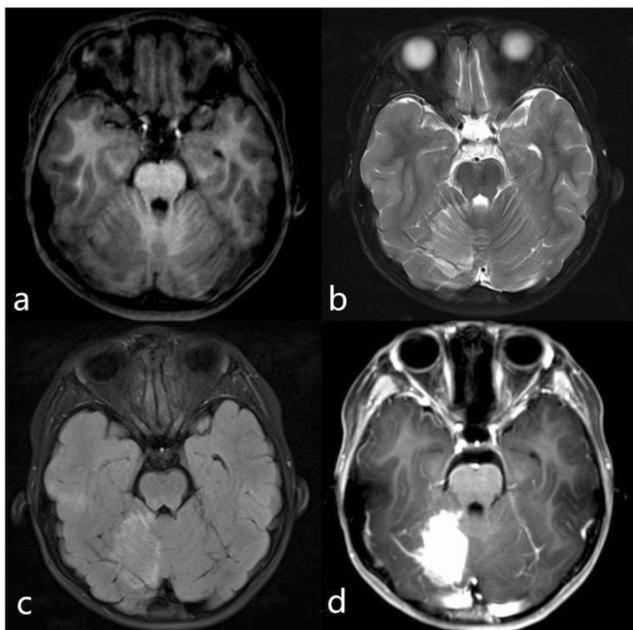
Conventional MRI of intracranial juvenile xanthogranuloma. The lesion was mildly hypointense on T1WI (a), heterogeneously hyperintense on T2WI (b), and mildly hyperintense on T2-flair images (c). Contrast-enhanced T1WI shows intense enhancement of the lesion (d)
